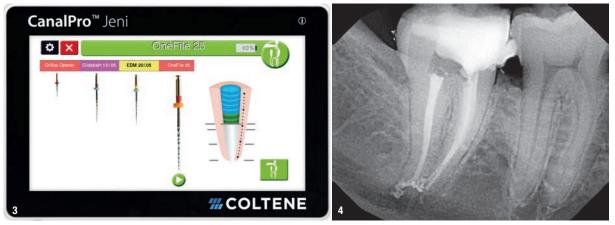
Choosing the sequence via touch screen. (© Coltène/Whaledent) Fig. 4: Course of the root canal in the post-op radiograph.
